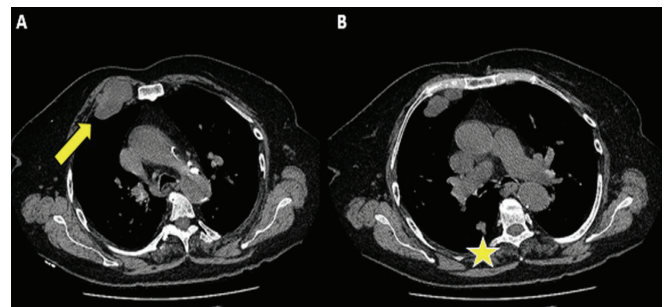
CT images of chest wall hamartoma (a) (arrow) and typical carcinoid tumor (b) (star).
